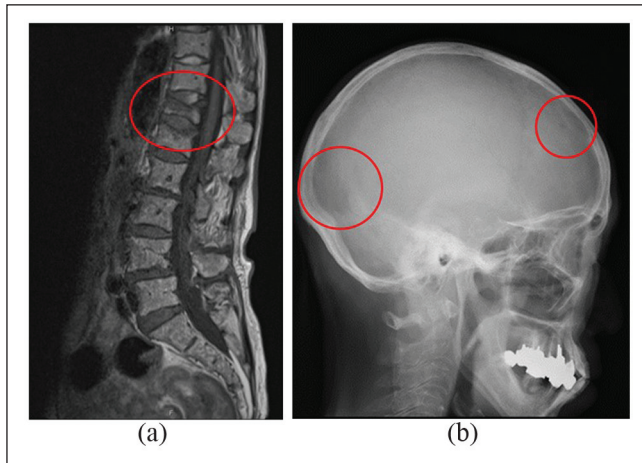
(a) Low T12 signal on lumbar T1-weighted MRI (red circle) and (b) punched-out lesion in the skull on a cranial radiograph were observed (red circles). MRI: magnetic resonance imaging.
